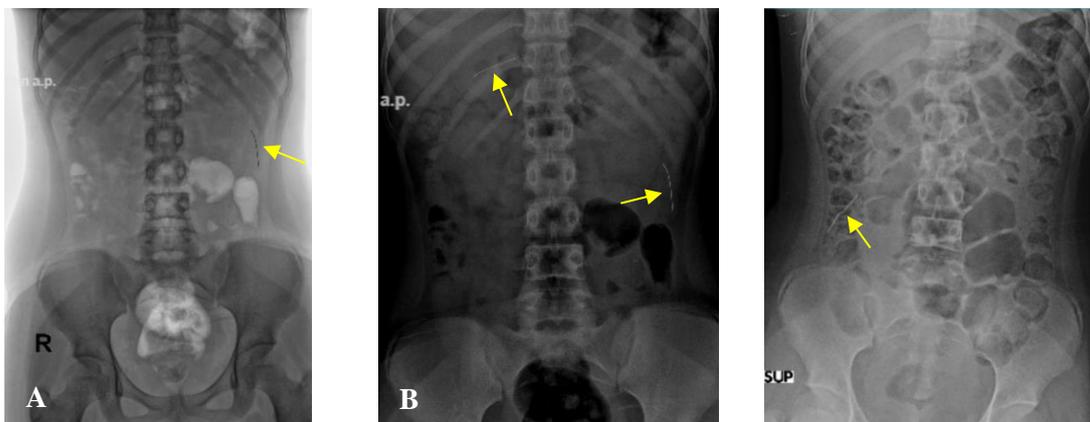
A, B. Abdominal X-ray showing needle-shaped metal density in the right hypochondrium region at region at the level of XI thoracic costovertebral joint and left lumbar region at the level of II-III lumbar costovertebral joint.
